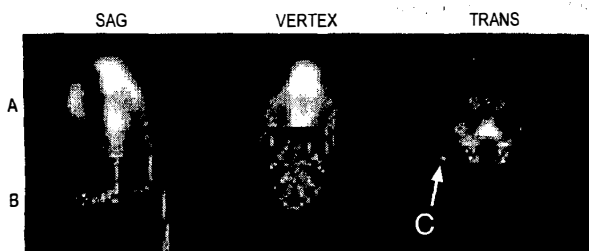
Partial overlays of AIR registered PET F-18 fluoride (A) and CT bone images (B). Note continuity of bones across the PET and CT image boundaries. C=capillary tube.
